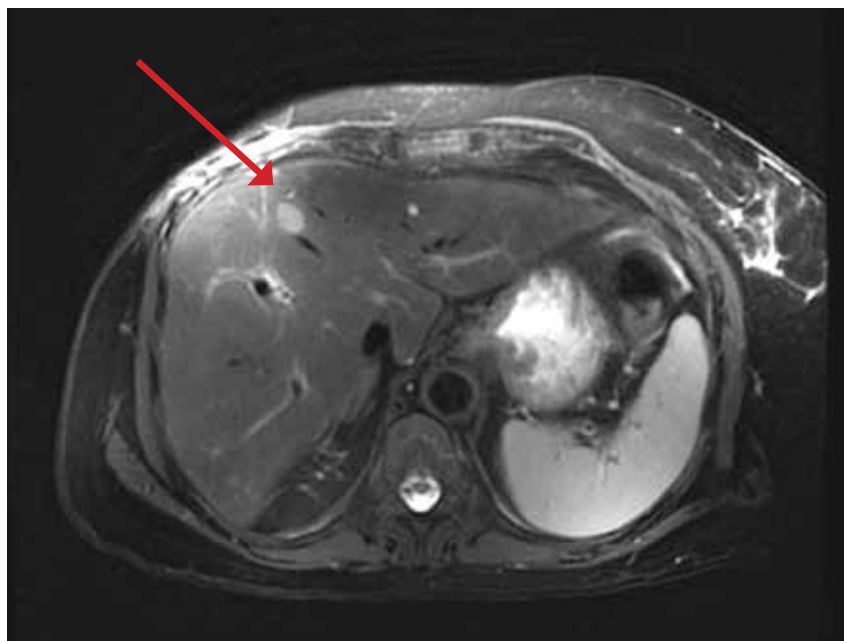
Fat-suppressed breath-hold MRI image acquired before ablation therapy shows hyperintense solitary liver metastases.
